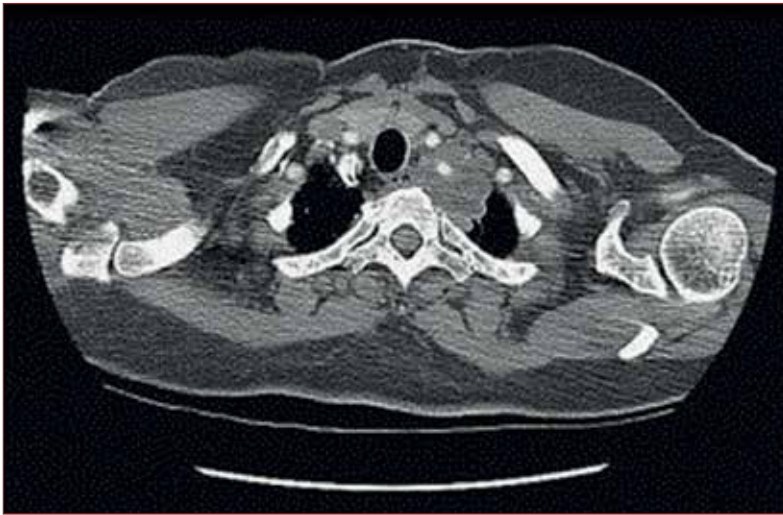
CT-scan showing vertebral T1 infiltration for non-small cell lung cancer
